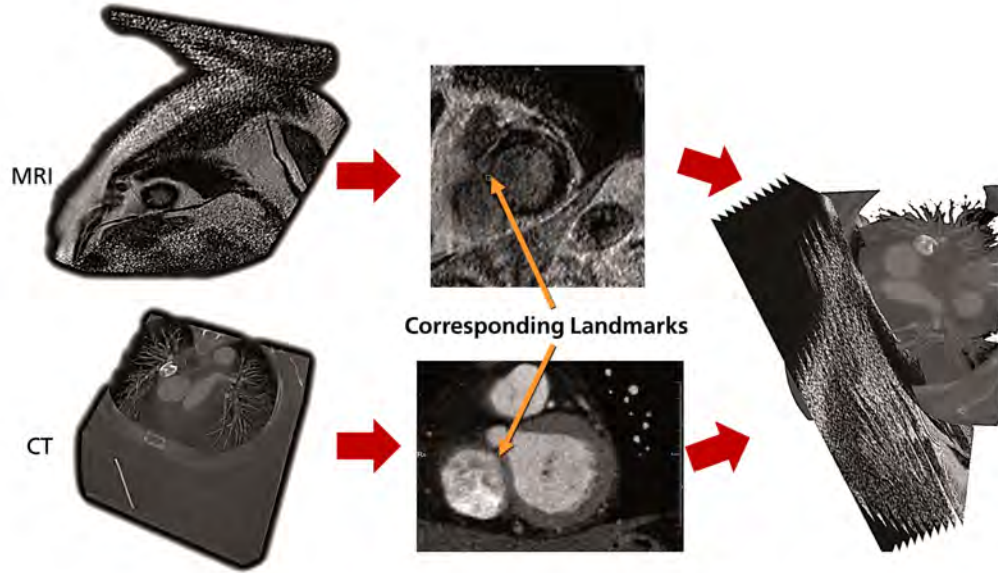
Initial alignment of CT and MRI datasets based on anatomical landmarks. This aligns the image coordinate systems without changing the image content (image data courtesy of PD Dr. med. H. Alkadhi, University Hospital Zurich).
